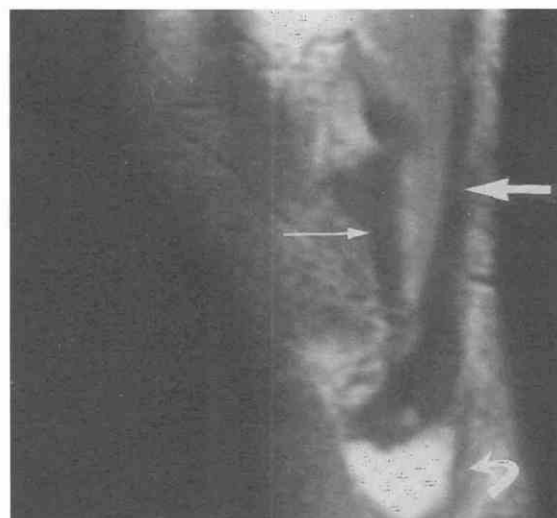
Conjoined tendon. Sagittal T1-weighted image, far lateral, shows the tendon of the biceps femoris (*thick arrow*) inserting with the fibular collateral ligament (*thin arrow*) as the conjoined tendon at the fibular head (*curved arrow*).
